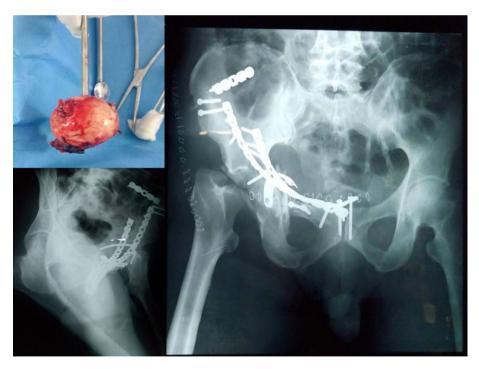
Stage 1 post op Plain radiograph showing Internal fixation of acetabulum fracture and absent femoral head (Source: original photo).
